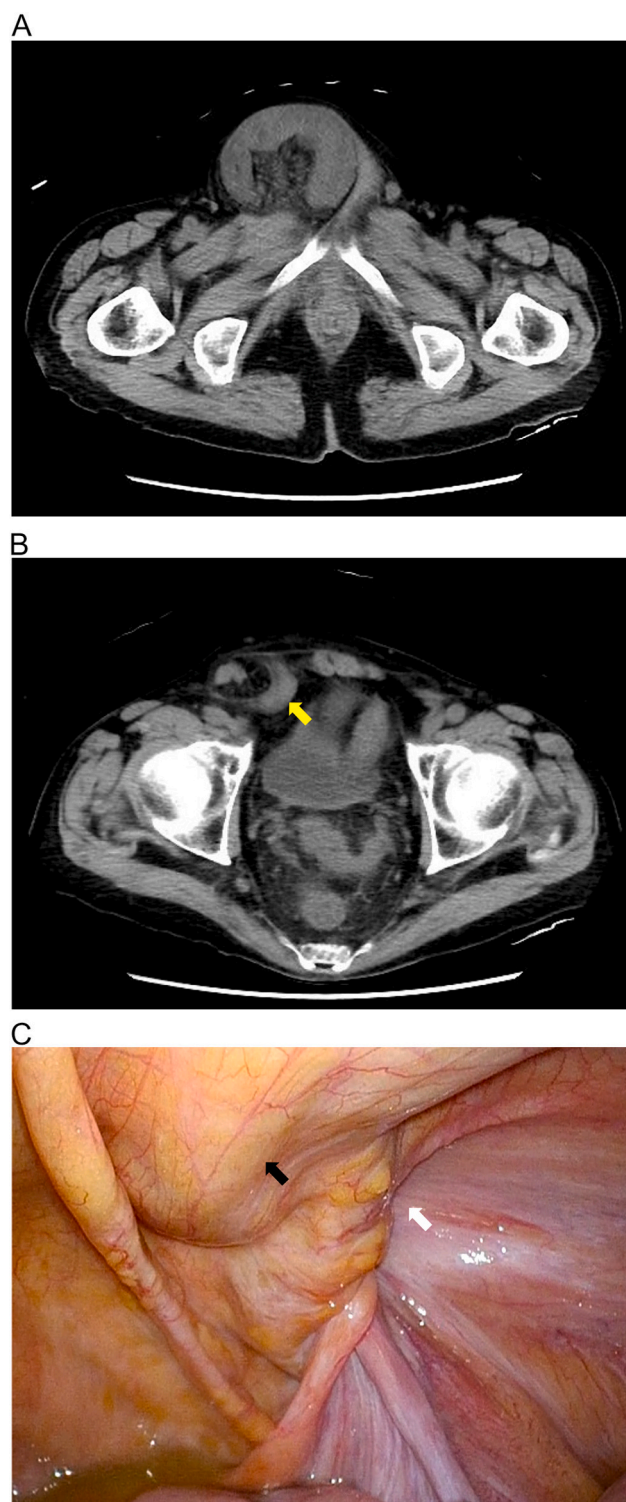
a: An abdominal CT scan revealed the small intestine was stuck into the scrotum.
